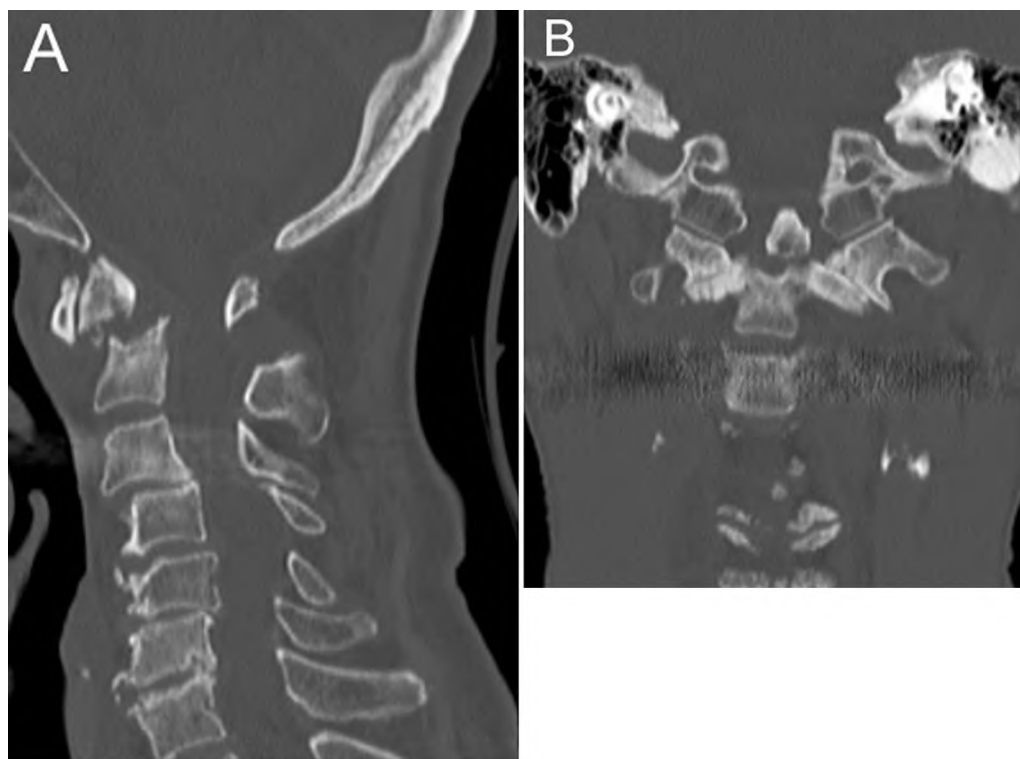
Sagittal (A) and coronal (B) CT reconstructions showing a mixed sclerotic and lucent lesion involving the atlas and a pathological fracture through the base of the dens.
